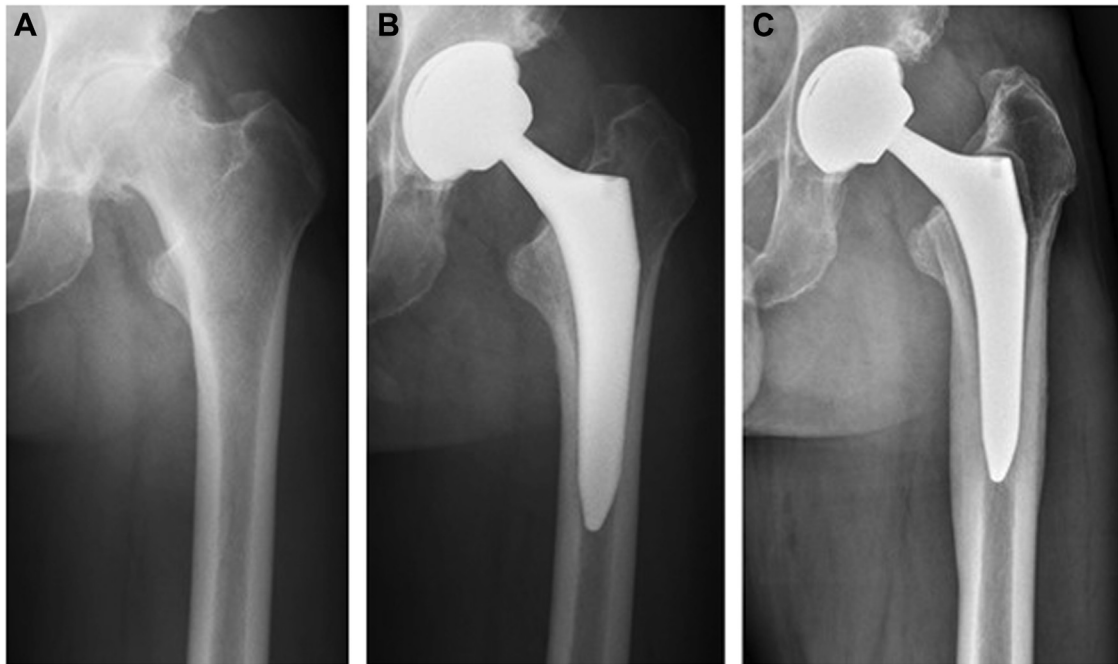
Radiographs of a patient obtained before surgery (A; Dorr type A femur), at 6 weeks after surgery (B) without symptoms, and at 3 years after surgery (C) with aseptic stem loosening before revision surgery.
